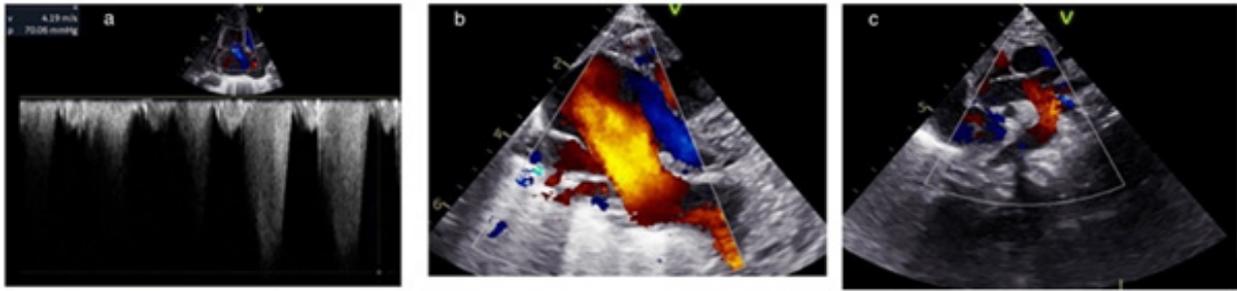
Echocardiogram on day 1 of life showed right heart chamber dilation, increased flow in the superior vena cava, signs of pulmonary hypertension, and diastolic retrograde flow in the descending aorta
